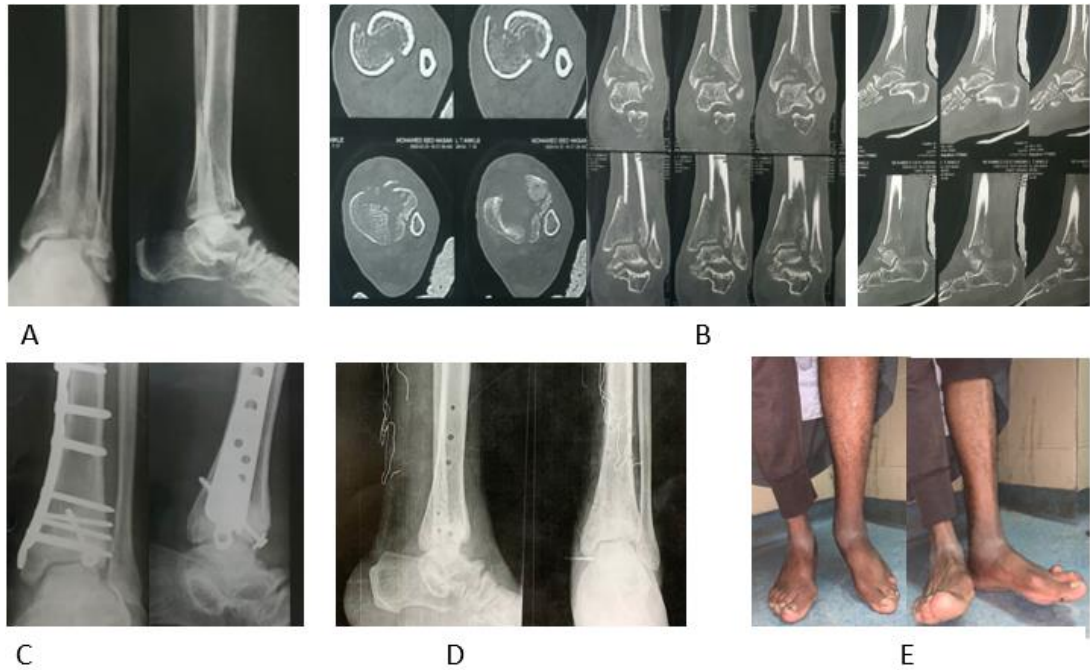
Male patient, 24 years old, falling from height (A) X-ray showed pilon fracture type B. (B) CT scan cuts show the degree of comminution and articular surface fracture lines. (C) four months post-operative x-ray showed healing of the fracture and fixation with the medial buttress plate and augmented by an additional anteroposterior lag screw for the anterolateral fragment. (D) X-ray showed removal of the implants and complete solid union, after a 13-month follow-up, there is mild ankle arthritis. (E) Clinical photos show accepted ankle range of motion 15-month follow-up.
